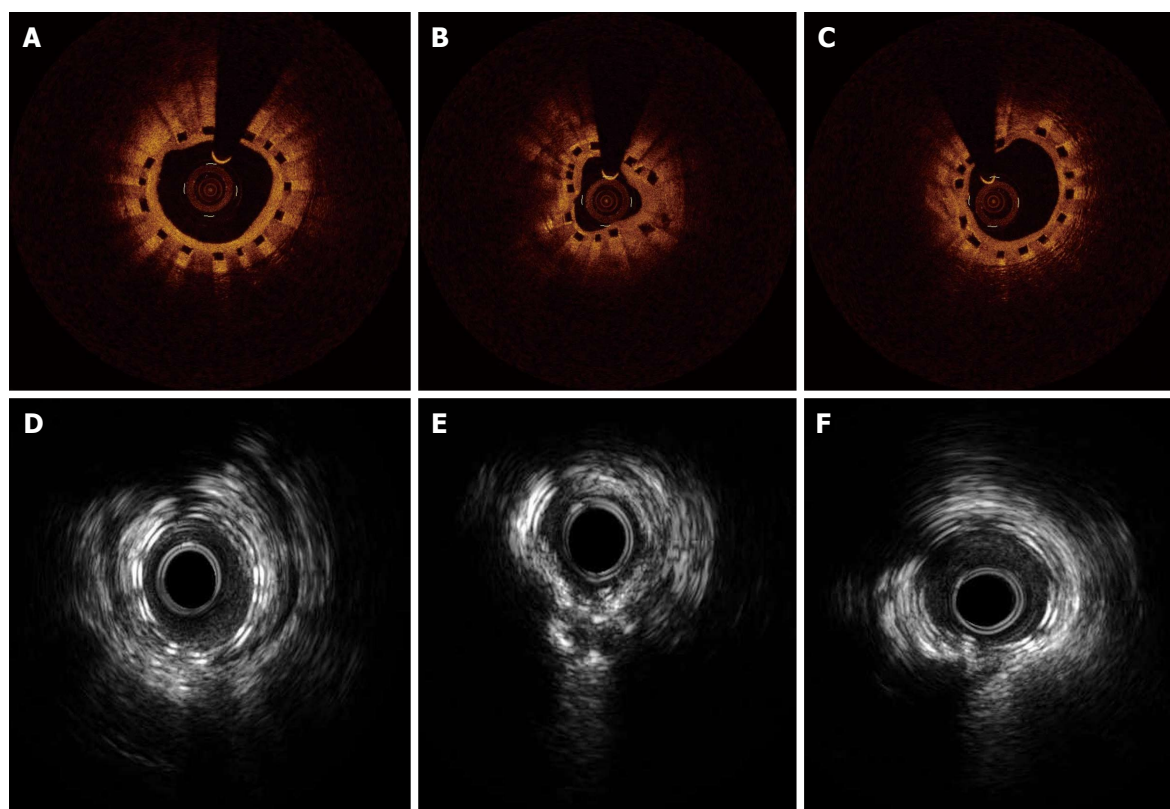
Intravascular ultrasound and optical coherence tomography findings 1 yr after bioabsorbable stent implantation. A-C: The OCT findings 12 mo after bioabsorbable scaffold implantation showed complete strut coverage; D-E: IVUS also shows uncovered struts in the same patient. IVUS: Intravascular ultrasound; OCT: Optical coherence tomography.
